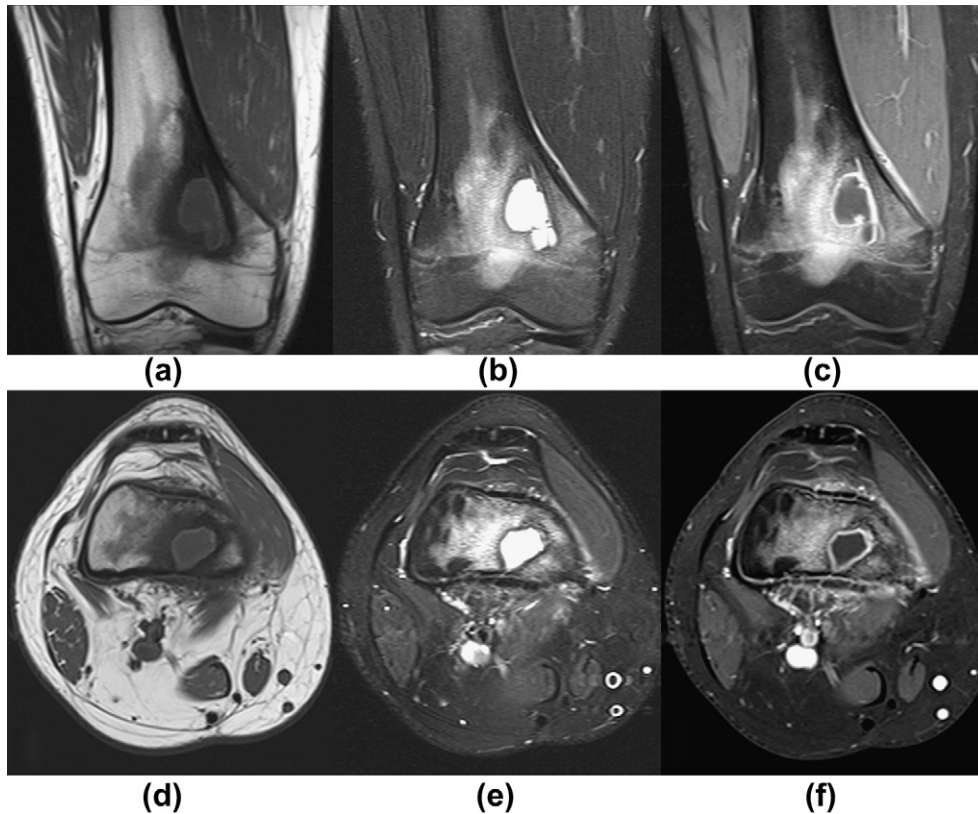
MRI image showing the Brodie's abscess. Coronal, (a) T1, (b) T2, (c) fat-saturated and contrast-enhanced MRI images. Axial, (d) T1, (e) T2, (f) fat-saturated, and contrast-enhanced MRI images. There is florid oedema in the surrounding marrow with peripheral enhancement of the wall of the structure with the oedema and enhancement extending across the growth plate after contrast medium injection.
